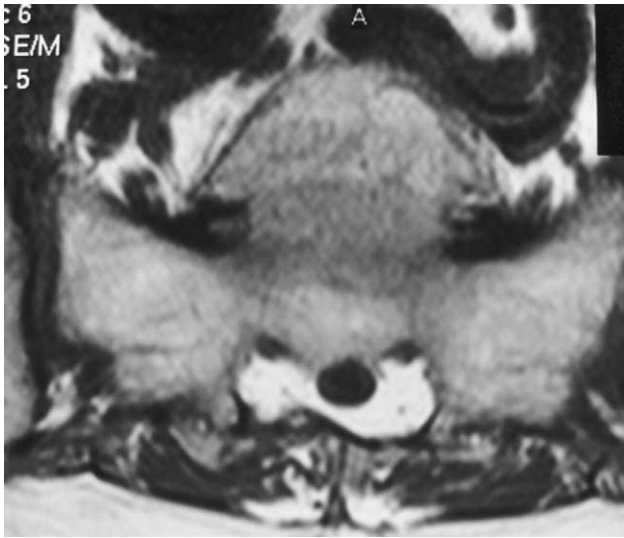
Axial T1-weighted MRI of lower lumbar region demonstrating bone bridge formation between L6 and S1.
